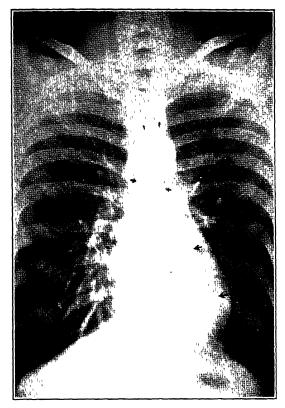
Same patient as in Fig 3 Contrast roentgenogram. Eight seconds after injection. The left auricle and the left ventricle are indicated by the middle and lowest arrows on the left side, a pulmonary vein by the lower right dart. The ascending aorta is enclosed by small arrows. Note the 2 branches from the aortic arch and the left axillary aftery. (Robb and Steinberg. Am J. Roentgenol.)
